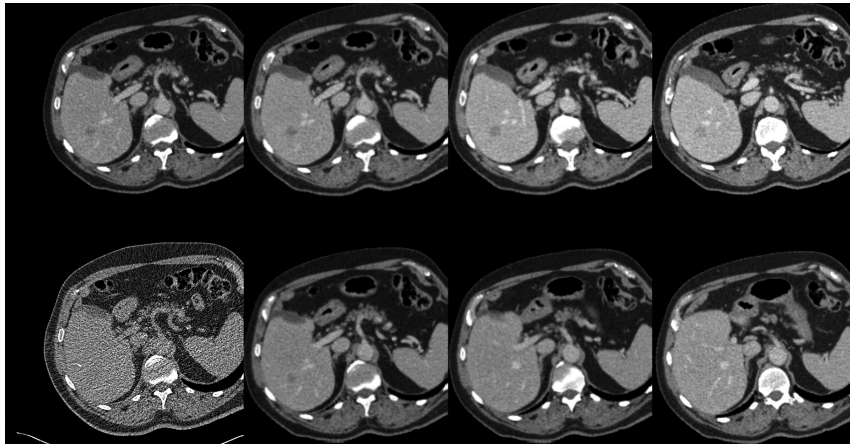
2D views of estimated slices for clinical data – results for the TASC algorithm. The first image column shows the CT-fluoro slice on the bottom and the estimated minimum at the top. The other images show slices on the valley floor created by the TASC algorithm.
